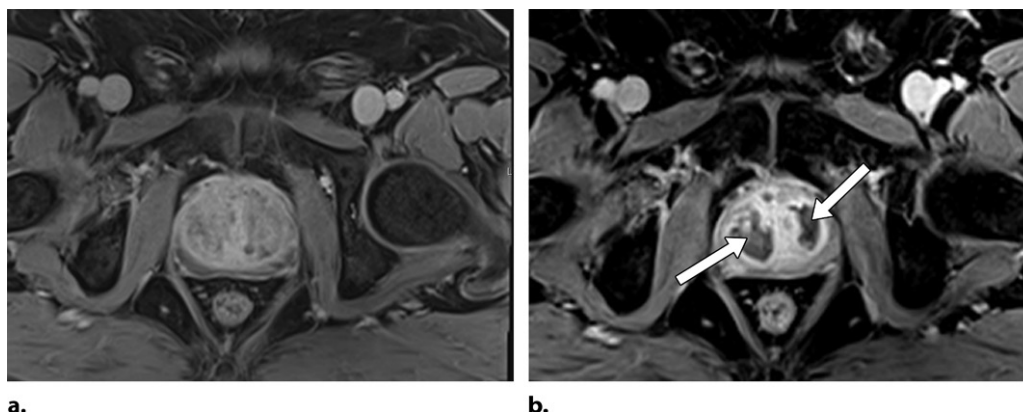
(a) Pre-PAE MR image in a 73-year-old man shows heterogeneously intense enhancement of the central gland due to different components of BPH. (b) Post-PAE MR image in the same patient shows the evolution of the infarction areas (arrows), which are called “black holes.”
